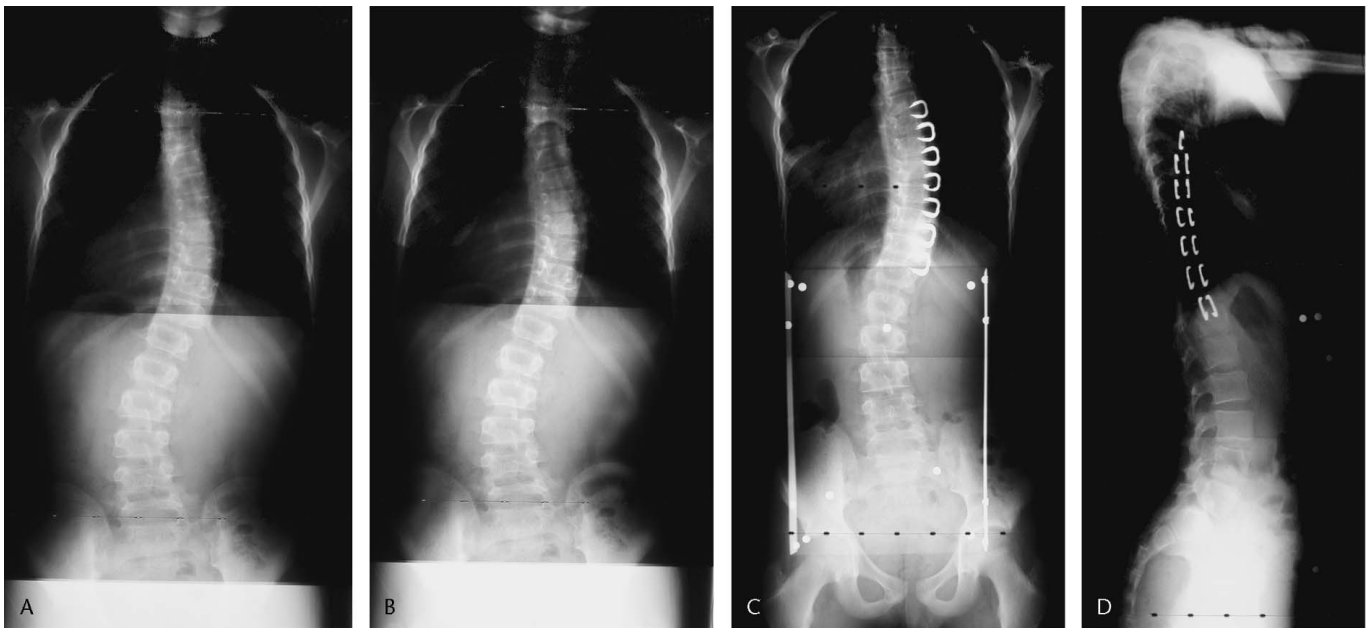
(A) This patient is a 10-year-old male with open triradiates (Risser 0). He presents with a 35° right thoracic curve. Magnetic resonance imaging is normal. (B) The patient is placed in a TLSO and returned in 1 year with an xray out of the brace. He is now 11 years old with progression to 42°. Two years after the patient’s vertebral body stapling of T6 through L1, (C) a posterior-anterior and (D) a lateral radiograph show the curve is maintained out of the brace at 28°. The patient wore a brace for 1 month postoperatively. Thereafter, no brace was required and there was no restriction of activities.
